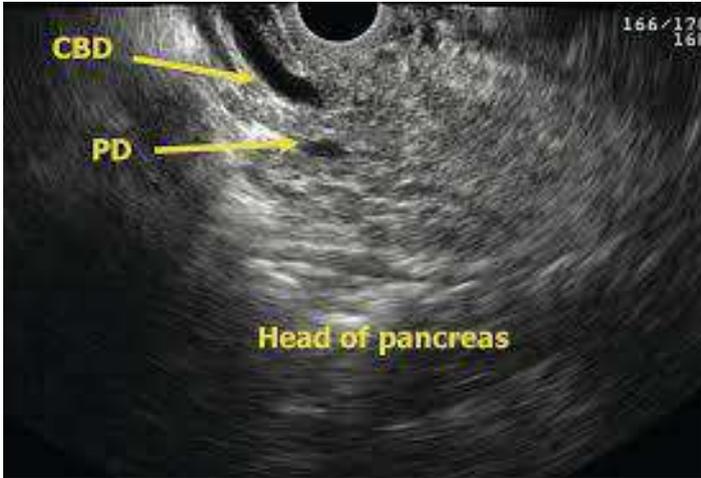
Pancreas Divisum (PD) in ultrasound picture
